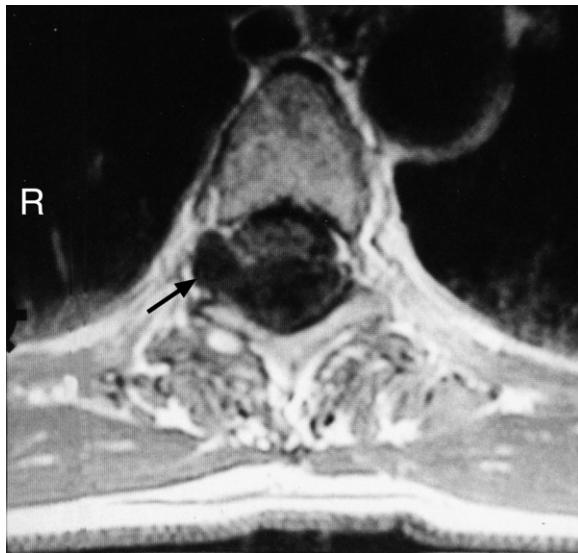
MRI axial T1-weighted post gadolinium image showing that the lesion is seen to encroach upon the T5–6 neural exit foramina, particularly on the right side (black arrow).
